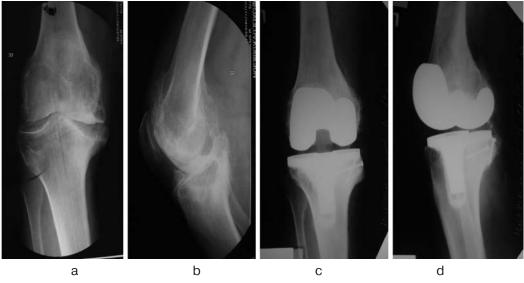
Roentgenograms of the right knee joint of the patient K.G. Before treatment (a, b) and after treatment (c, d)
